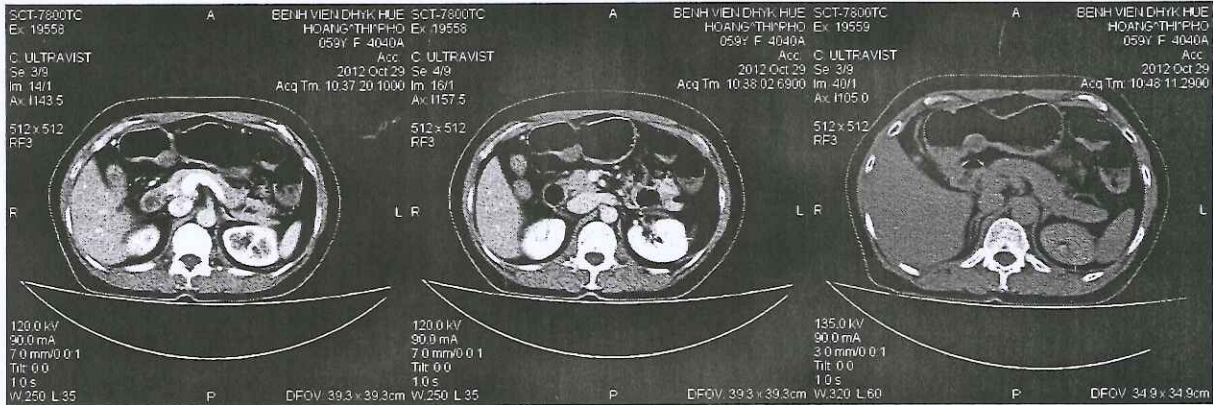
Axial contrast-enhanced computed tomography (CECT) showed a well-defined, ovoid, homogeneous, intramural mass arising from the gastric antrum with slightly enhancement. The mass was measured 2 cm in diameter. There was no evidence of adjacent tissue infiltration or lymphadenopathy or ascites. CT scan findings were suggestive of a gastric GIST.
